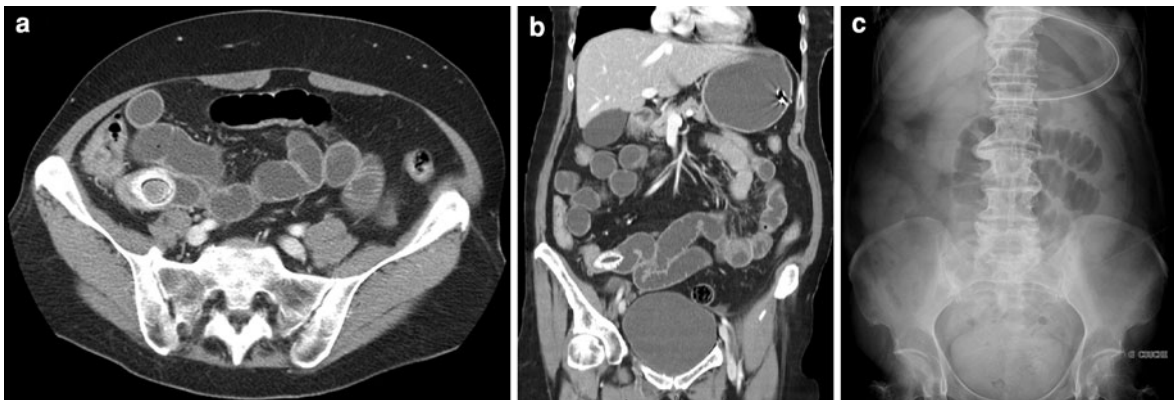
SBO due to gallstone ileus. The axial slice (a) and coronal reformatting (b) clearly show the stone responsible for the SBO. Note that the stone is not seen on the abdominal plain film (c) and that most of the bowel loops do not contain air
